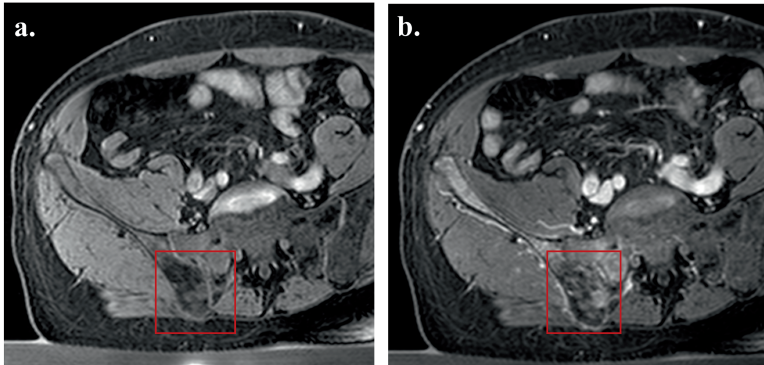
MR images acquired post-treatment before (a.) and after (b.) gadolinium injection from a patient with an osteoblastic metastasis (within the red box) in the pelvis. After contrast injection, it is possible to identify a hypointense region in the metastasis. However, it is hard to assess if this is a treatment effect or only inherent to the blastic character (mainly composed by bone) of the metastasis, as a low-signal region was visible in the metastasis also prior to contrast injection.
